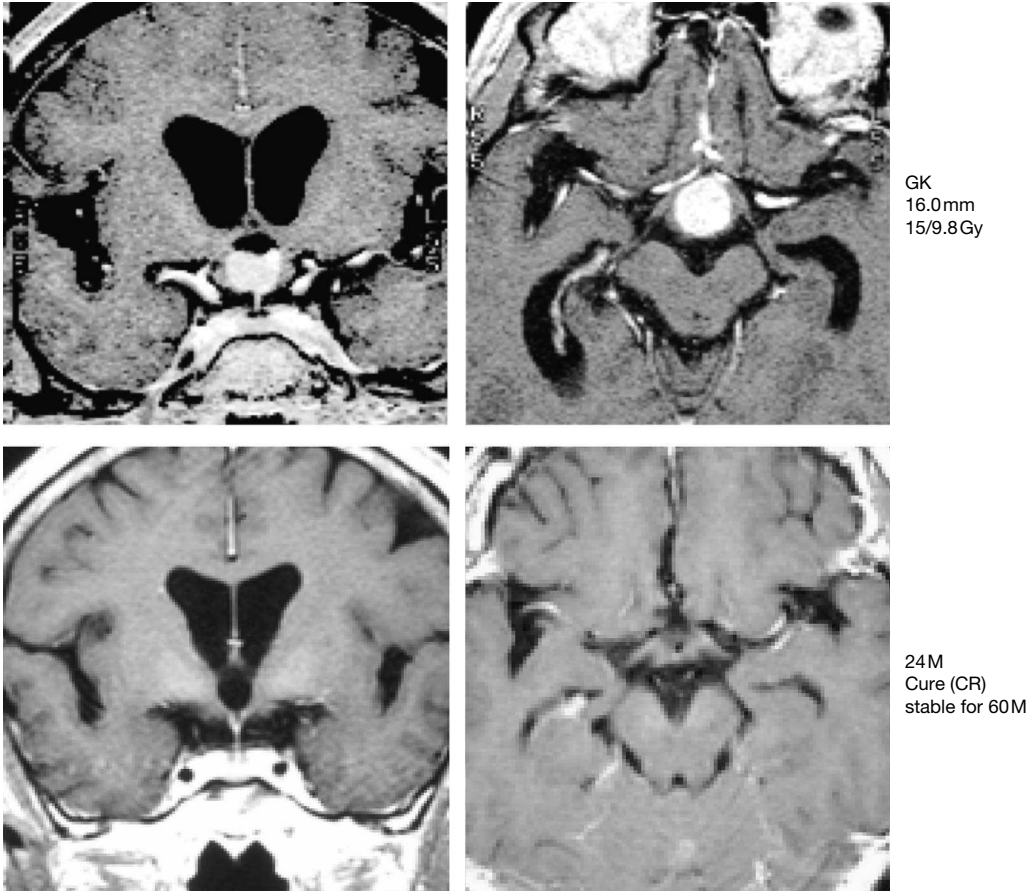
Small tumor at ‘R-site’ and follow-up MRI after GK. A 52-year-old man had a suprasellar, solid mass and hydrocephalus with memory loss and visual acuity disturbance. After biopsy via the lamina terminalis approach, a small tumor in the third ventricle (15.9mm) was treated by GK radiosurgery with a marginal dose of 9.85 Gy. The tumor showed CR at 24 months and has been stable for more than 5 years, to date, with improvement of symptoms.
